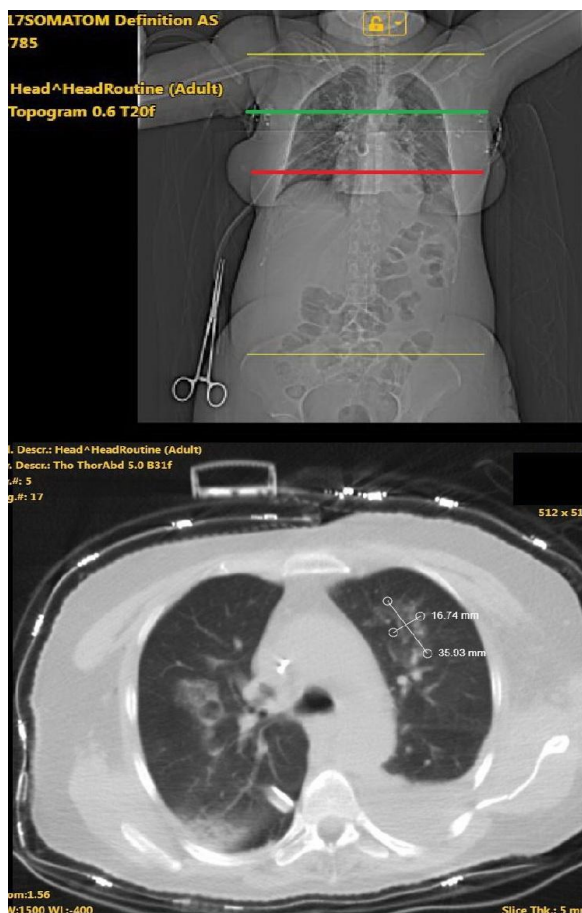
A CT scan of the thorax of patient 1
